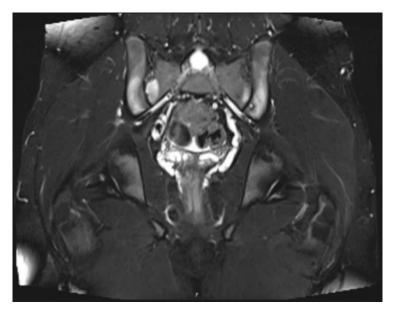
Magnetic Resonance Imaging (MRI) of the pelvis, with fat saturation following gadolinium contrast administration, showing bone marrow edema, subchondral sclerosis and irregularity of the articular surfaces of both sacroiliac joints.
